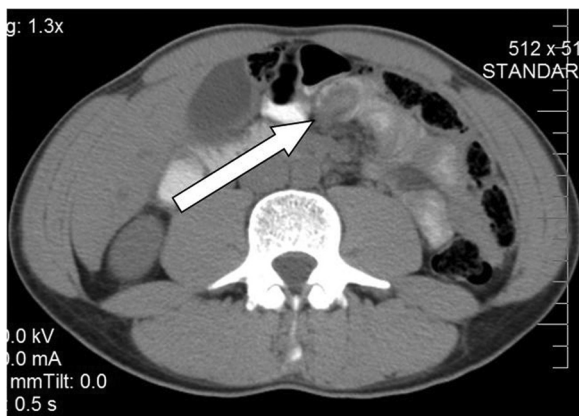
CT Abdomen/Pelvis with oral contrast.
